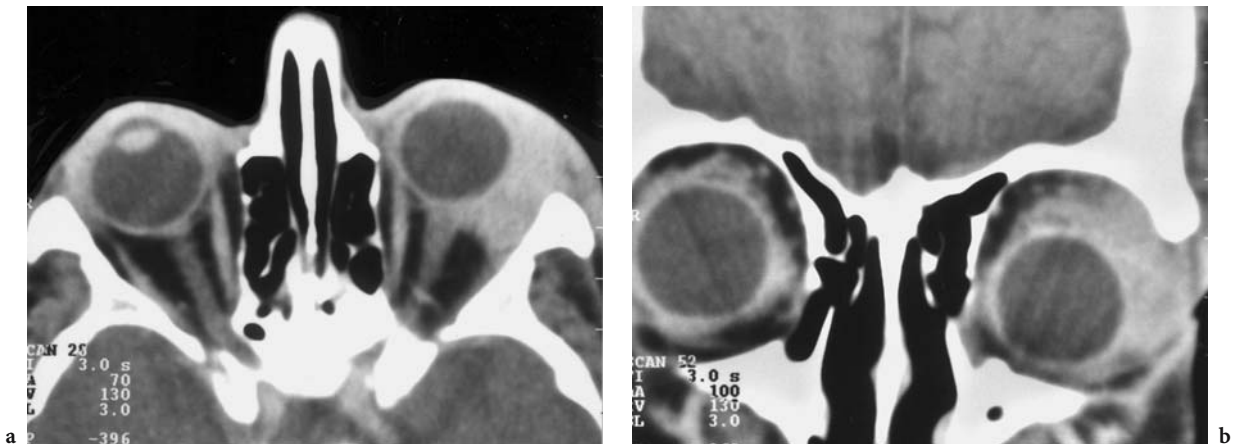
A 61-year-old man with slowly progressing protrusion of the intermittently infected left eye. Diagnosis: chronic sclerosing dacryoadenitis. Contrast-enhanced CT: a Axial view demonstrating global enlargement of the lacrimal gland, and indistinct differentiation in the absence of compression of the globe. b Coronal view with irregular encasement of the globe
